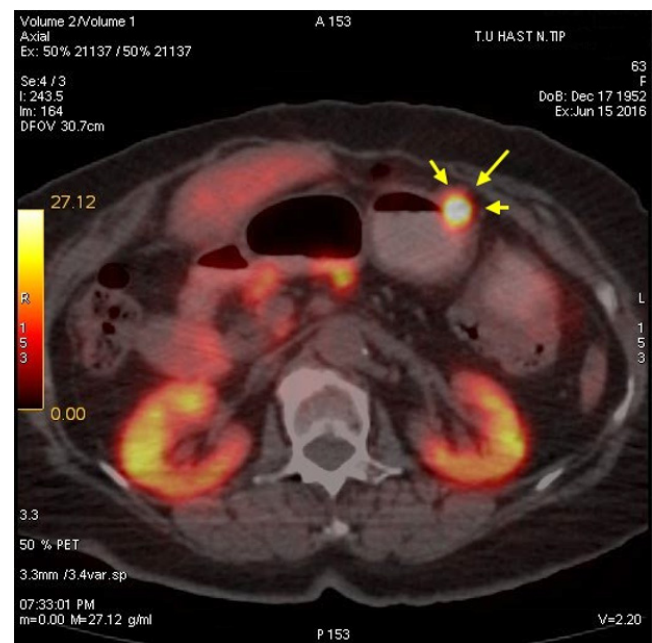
The involvement of the lymph node which is adjacent to the stomach wall (Transaxial PET CT Fusion)
